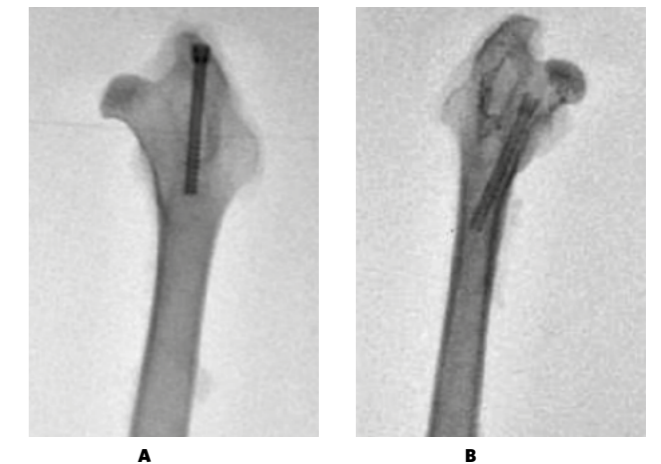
Radiographs of the femoral bone in 2 months: A — a titanium screw; B — BDI, its clear contours are visible, the lack of reaction of the surrounding tissues
